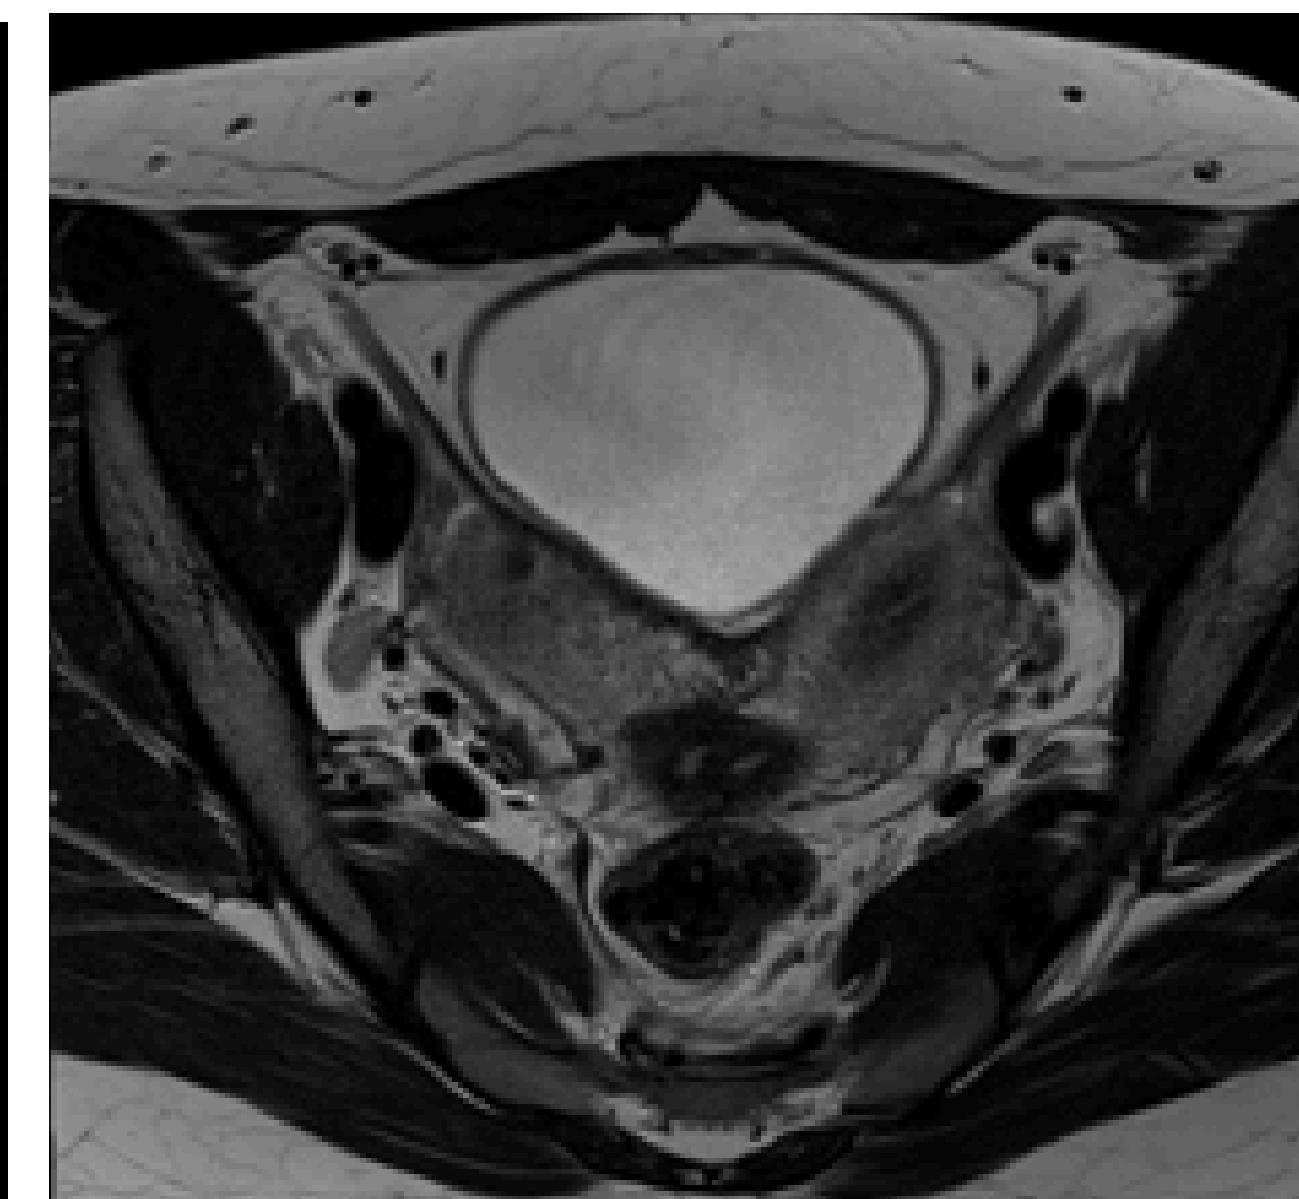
MRI Pelvis. T2 Axial demonstrating fundus and body of each component of uterus.
